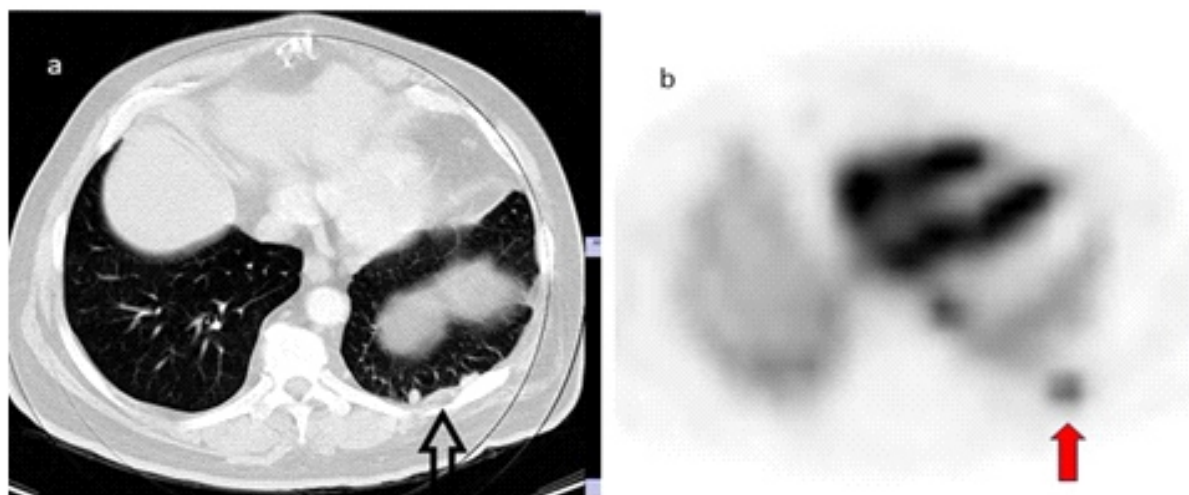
a) Thoracic CT shows a multiple nodular lesion measuring 11×7mm in the pleura adjacent to the posterobasal segment of the left lower lobe of the lung (arrow). b) Selective spleen scintigraphy SPECT transaxial section reveals focal activity (red arrow) beneath the costal margin, located in the pleura adjacent to the posterobasal segment of the left lower lung lobe.
